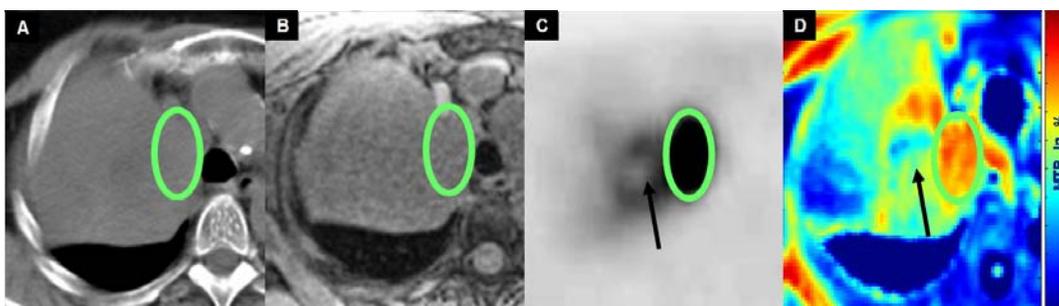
A) Diagnostic contrast enhanced CT. B) Corresponding VIBE image. C) FDG-PET image of same slice. D) Color-coded MTR map. The ovals depict the area of FDG-PET indicated metabolically active tumor which corresponds to the area of high MTR values. The arrows point to metabolically low active tumor tissue corresponding to low MTR.
